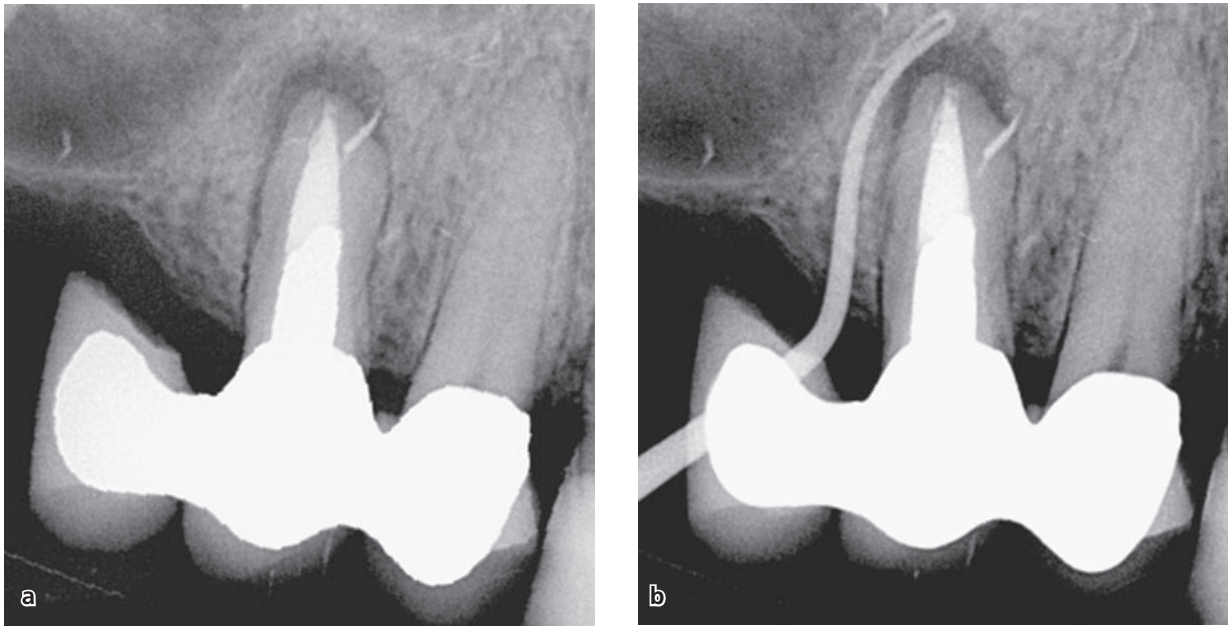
(a) Periapical radiolucency associated with an upper second premolar that turned out to be caused by a vertical root fracture. There was a buccal, deep pocket-probing depth and a sinus tract near the gingival margin. (b) A gutta-percha point inserted in the fistulous tract points to the root apex but provided no additional clue in this case. The widely prepared root canal and the use of the tooth as an abutment in a cantilever bridge provided likely contributors to the fracture in this case kindly provided by Dr. Thomas Kvist.
